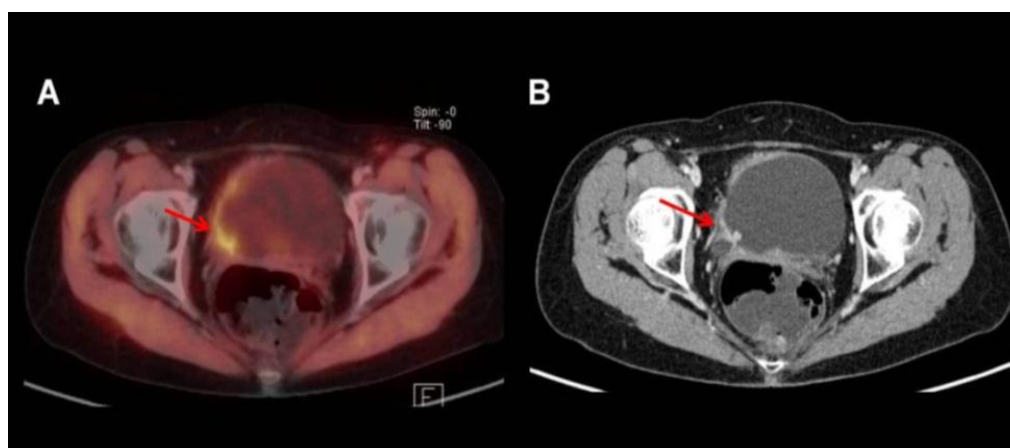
Bladder tumor with tracer uptake in the right posterior-lateral bladder wall as visualized by ^{11}C Choline-PET/CT. Note that there is excellent delineation of tumor and bladder lumen due to the fact that ^{11}C -Choline is usually not excreted by the urine (A: fused dataset). However, anatomical detail is superior in the contrast enhanced CT part of the PET/CT (B).
